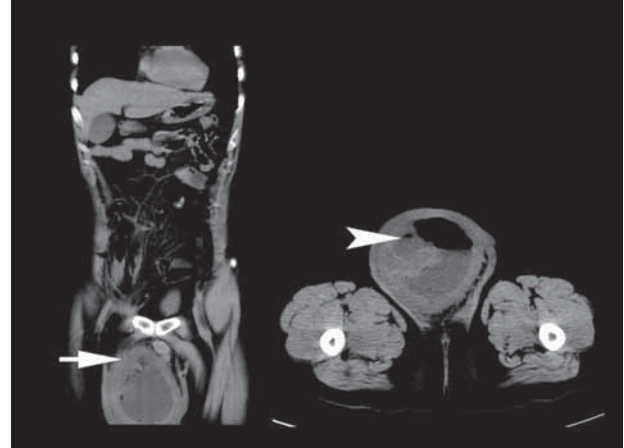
Non-contrast computed tomography of abdomen revealed intraperitoneal communication through a muscular defect and entrapped thick-walled colon within the right inguinal hernia (arrow), with air-fluid levels and fluid accumulation within a focal mass-like lesion (arrowhead).
